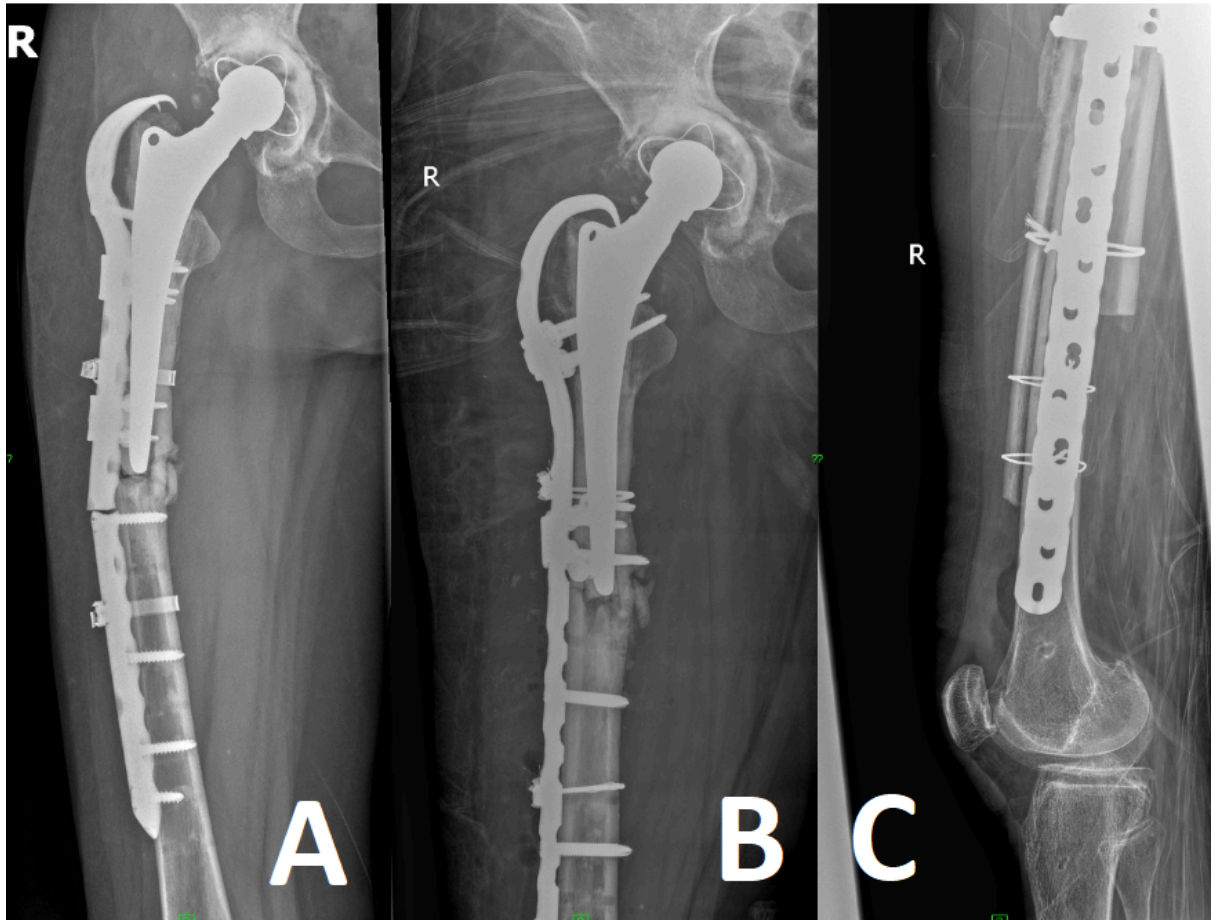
A: an AP preoperative x-ray showing the broken plate. B, C: Two directional postoperative X ray of a Locking Compression Plate (LCP) type Proximal Femoral Hook Plate (PFHP) with attachments and a bone autograft to reinforce stability and neutralize stress on the fractured area
